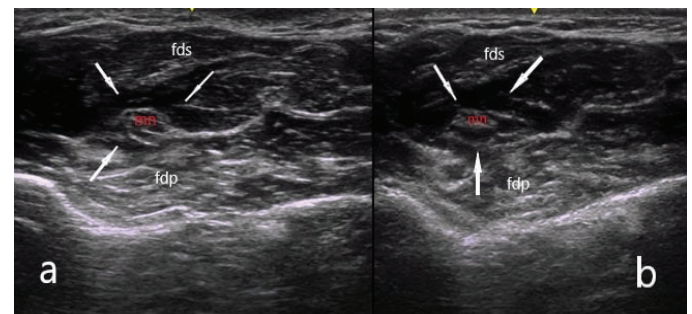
Axial ultrasound image of the median nerve during hydrodissection in proximal third of the forearm at first application (a) and second application (b). The space created by hydrodissection around the nerve (anechoic area, arrows) is seen. The change in the median nerve cross-sectional area in the month between the two applications is remarkable
